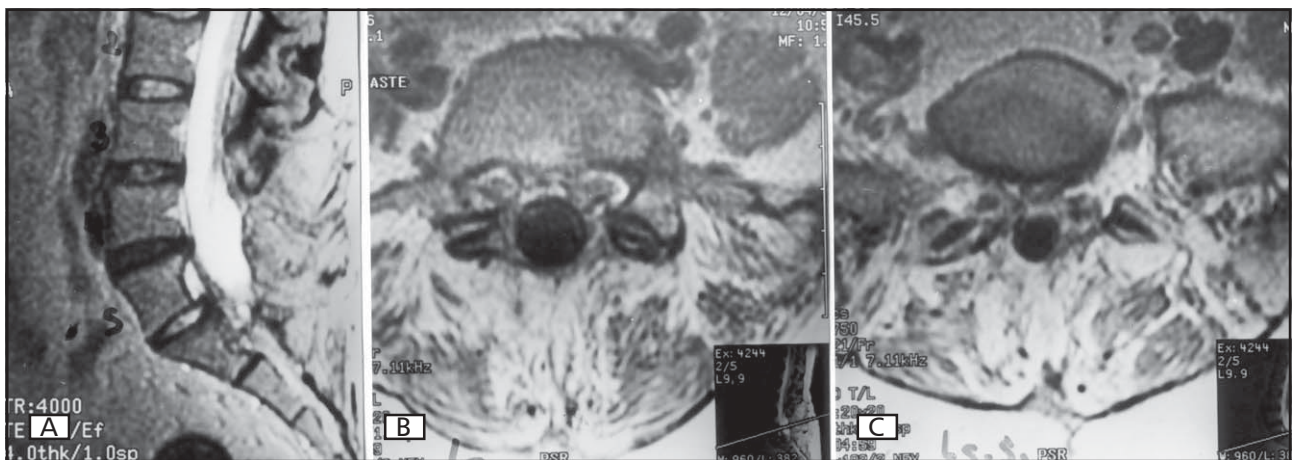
Postoperative MRI scans. A, sagittal T2-weighted scan. B,C axial T1-weighted scans with gadolinium infusion showing complete resection of the tumor.
